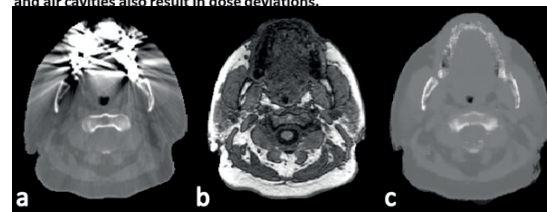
Transversal slice of CT (a), corresponding MRI (b) and sCT (c). The CT shows severe dental artefacts (excluded from the training data), whereas the generated sCT is without streaking artefacts.
